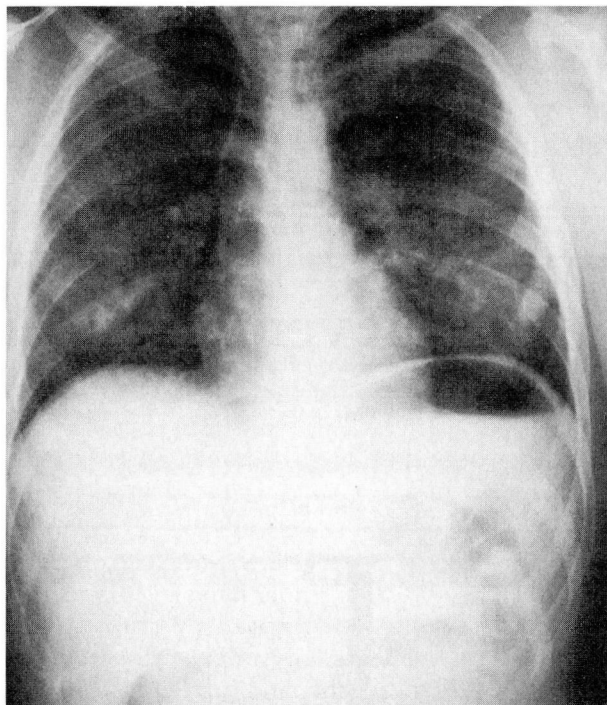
Chest roentgenogram on admission (left) demonstrating bilateral alveolar infiltrates, which cleared within 24 hours (right).
